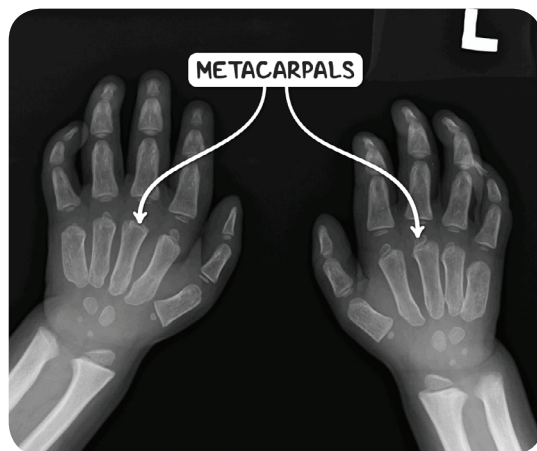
X-ray image of the hands of an infant with Hurler syndrome. The metacarpals are pointed at the proximal ends.
